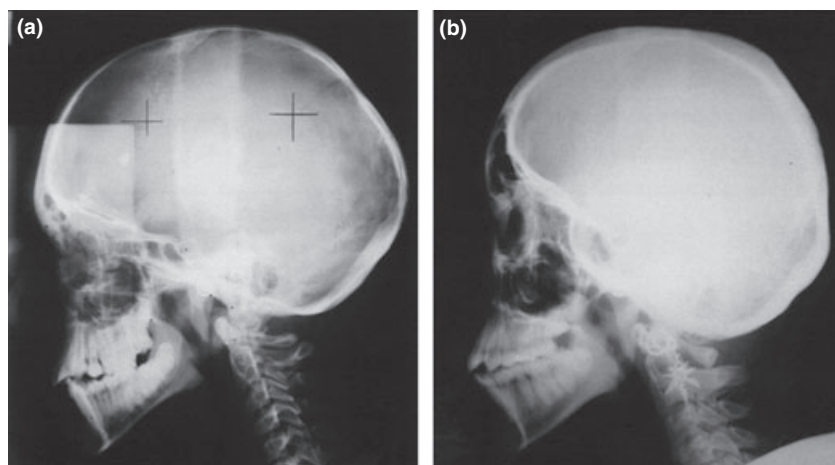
(a) Profile radiograph of a girl with SMMCI aged 10 years 7 months. (b) Profile radiograph of a girl with SMMCI aged 17 years 0 months.
